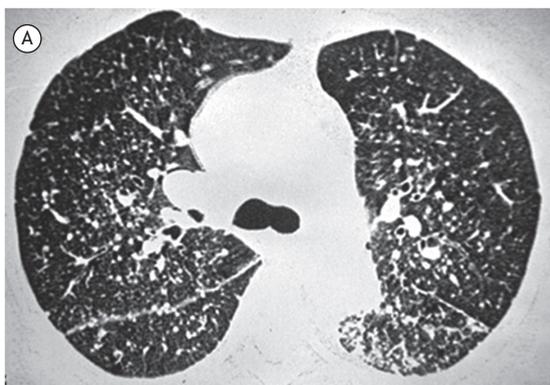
HRCT scans with lung window settings at the level of the bronchial bifurcation evidence small interstitial nodules distributed in the lungs. Note that there is an accumulation of nodules along the fissures (detail in B), characterizing the pattern of nodular fissure.
